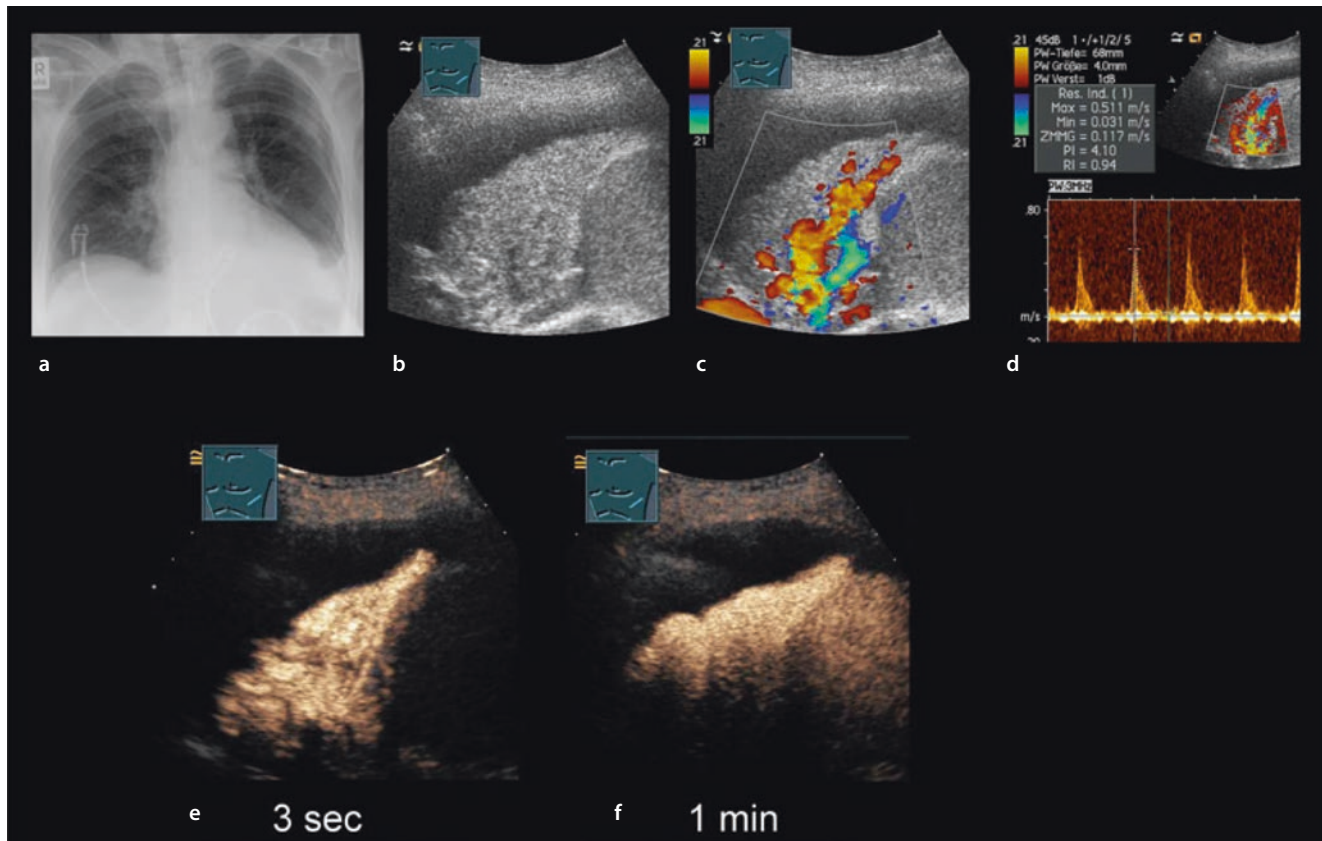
a Man with a left-sided pleural effusion on the chest X-ray. b The B-mode image shows a homogeneous consolidation as in the presence of atelectasis. c Color Doppler ultrasound reveals specifically directed and pronounced vessels. d On spectral curve analysis the arterial centrifugal vessels show a high-impedance flow
